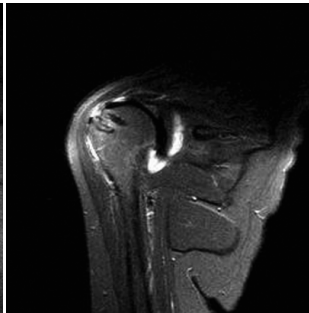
Coronal T1-weighted image showing partial rotator cuff tear with delamination. Note the absence of contrast material in the subacromial-subdeltoid space after double row repair.
